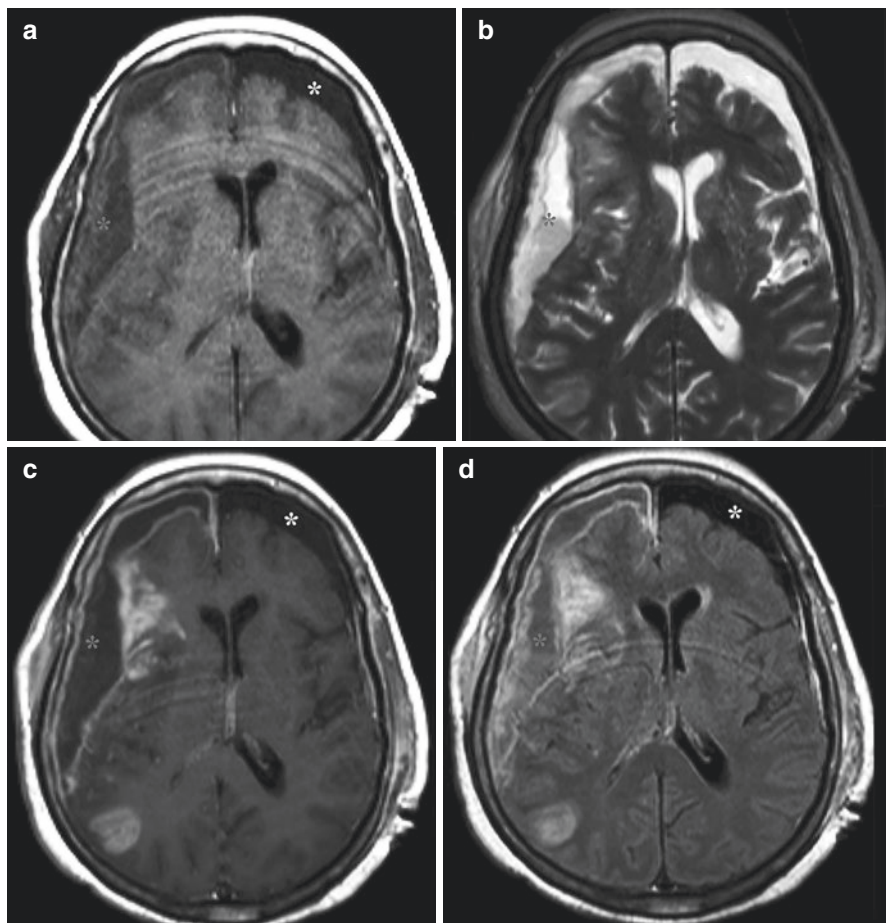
Bilateral subdural collection is observed in the contrast-enhanced brain MRI examination of a 61-year-old male patient. Both collections are seen as (a) hypointense on T1 and hyperintense on T2 (b). It is noteworthy that the content of the collection on the right is more intense and gives fluid-fluid layering (red asterisk) due to hematocrit effect. On contrast-enhanced T1 (c), significant enhancement was observed in the dura accompanied by adjacent cerebral parenchymal and leptomeningeal enhancement. On postcontrast FLAIR image (d), thickening of the dura, a subdural collection with heterogeneous hyperintense to the CSF and signal increases due to parenchymal involvement were observed. The collection on the left side was homogeneously isointense with CSF in all sequences and did not show any enhancement. Findings show that the right-sided collection was an empyema secondary to meningo-encephalitis, and the left collection was subdural hygroma
